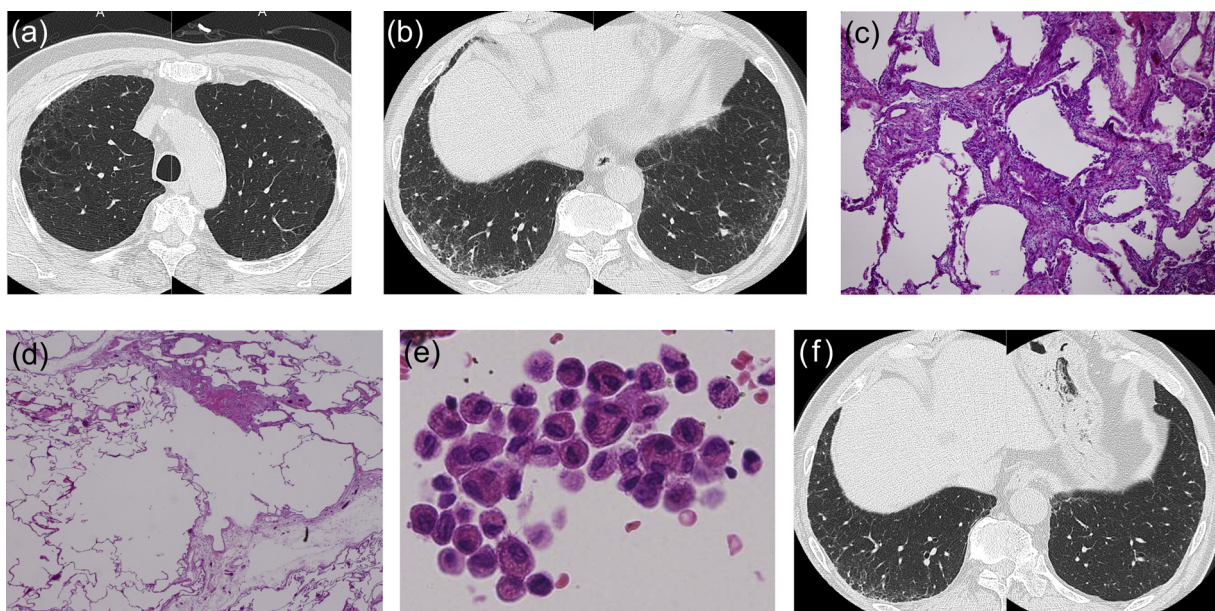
HRCT images (a–b, before surgical biopsy; f, 4 months after the cessation of smoking) and pathological findings (c–e). (a) the upper zones of the lungs showing paraseptal and centrilobular emphysema. (b) the lower zones of the lungs showing ground-glass opacity and reticular patterns. (c) irregular interstitial fibrosis with mild chronic inflammation. (d) emphysema in the non-fibrotic lesion. (e) intraluminal accumulation of macrophages. (f) marked improvements in ground-glass opacity and reticular patterns.
